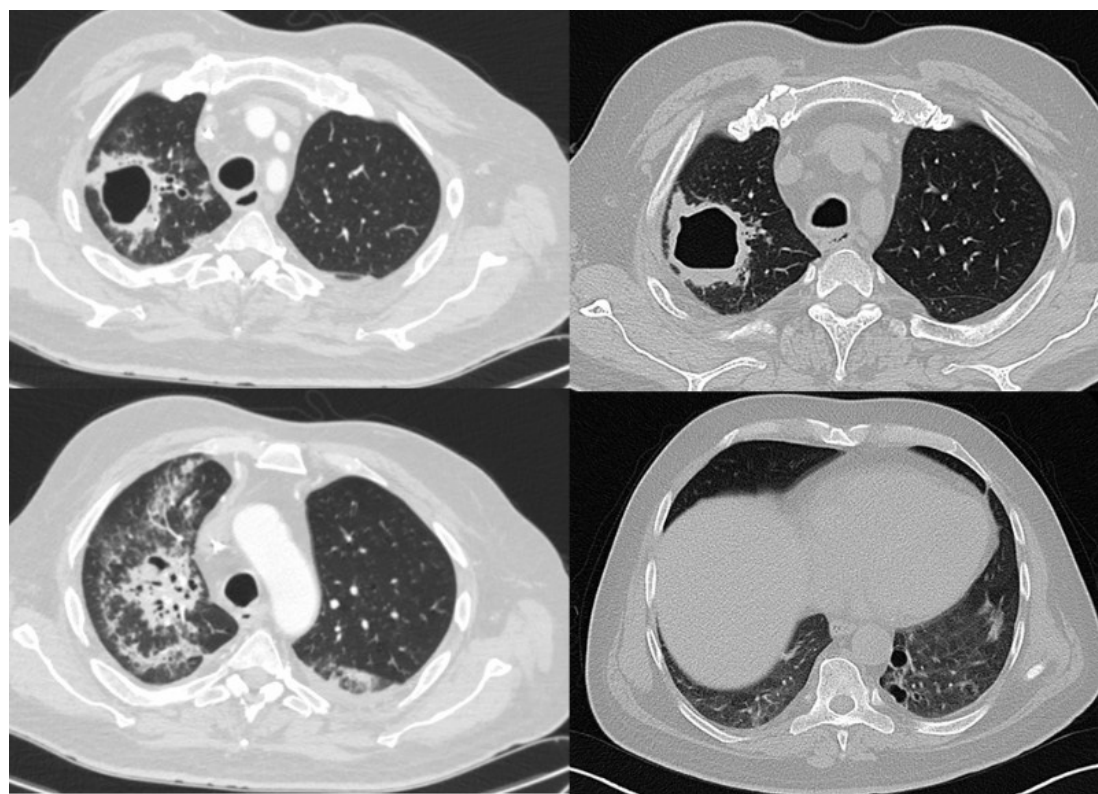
Thorax CT showing multiple cavitory lung lesions
